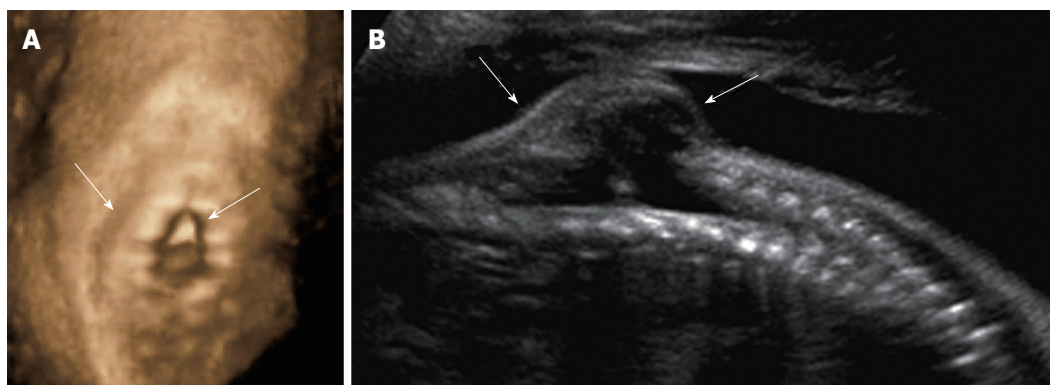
Spinal dysraphism ultrasound. Coronal 3D (A) and sagittal 2D (B) ultrasound images of the 26 wk fetal spine demonstrate dysraphism of the thoracolumbar junction (arrows), in the region of known myelomeningocele.
